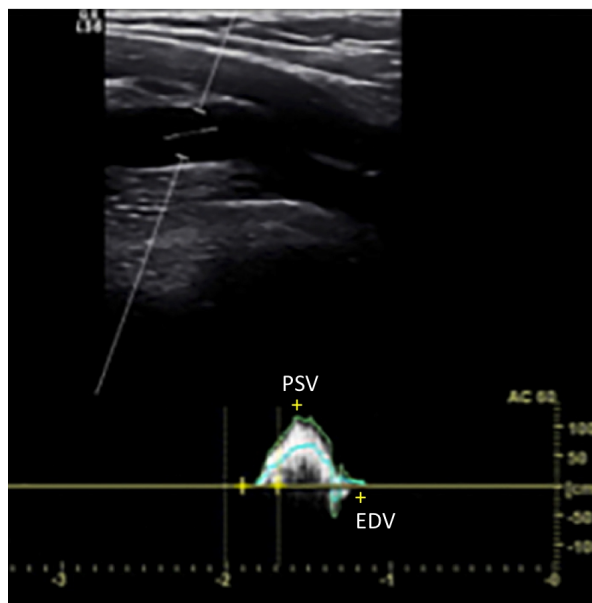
Objective sonographic parameters assessment: ultrasound scanning allows measurement of objective parameters such as peak systolic velocity (PSV)(highest velocity during the systolic phase) and end diastolic velocity (EDV)(velocity at the end of the diastole). From PSV and EDV, the resistance index can be calculated (PSV/PSV-EDV).
